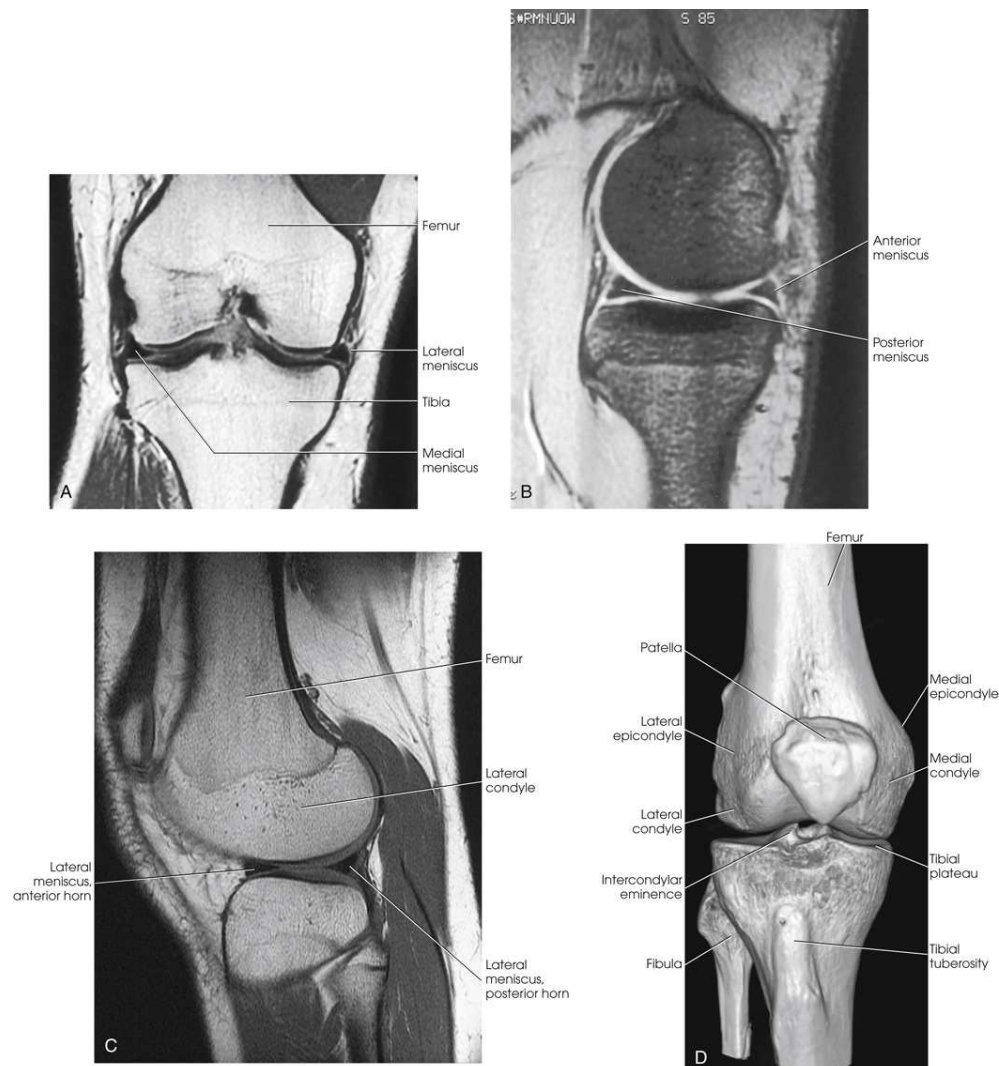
(A) MRI coronal plane. (B) MRI sagittal plane. (C) MRI oblique plane. (D) Three-dimensional CT reformat of the knee joint.
